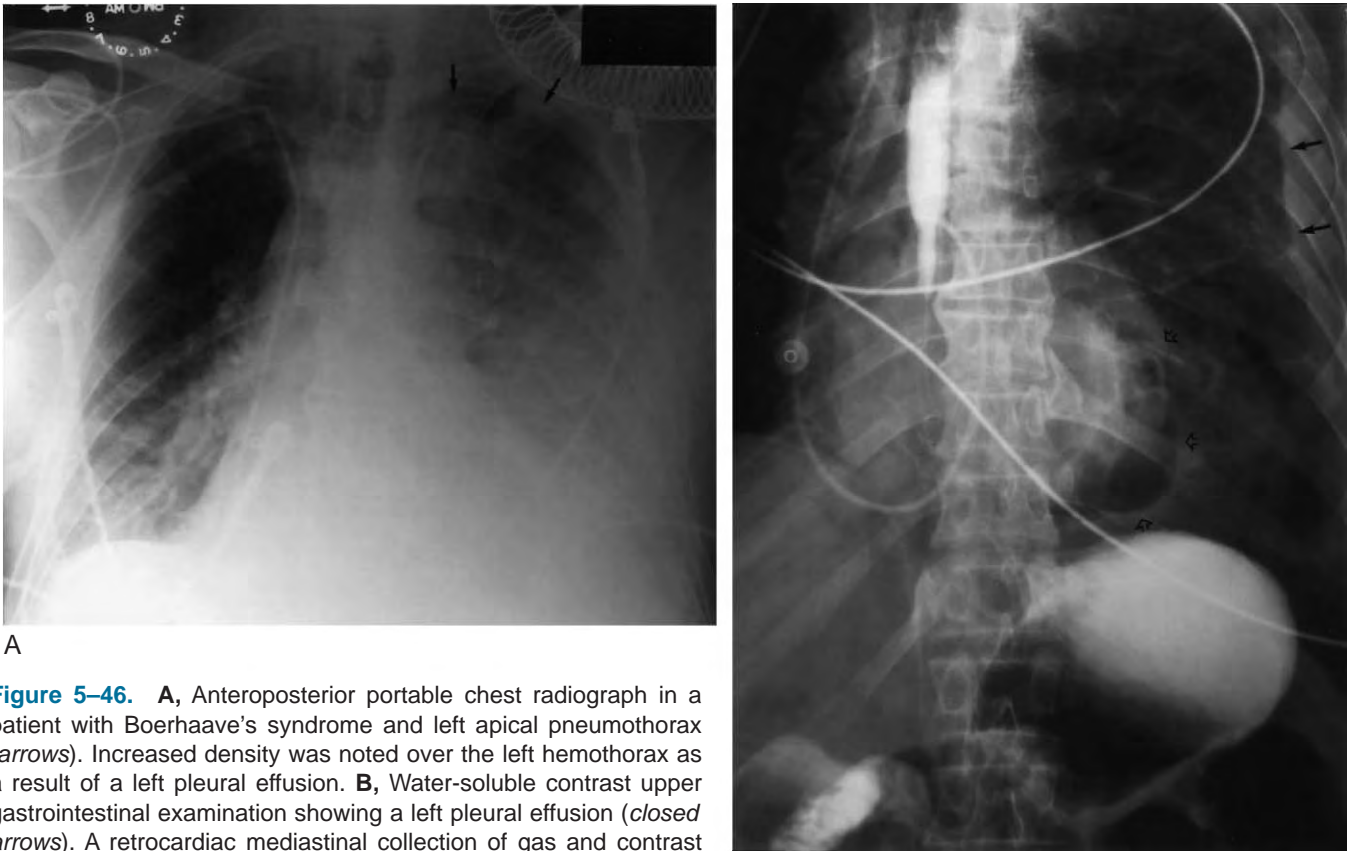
A, Anteroposterior portable chest radiograph in a patient with Boerhaave's syndrome and left apical pneumothorax (arrows). Increased density was noted over the left hemithorax as a result of a left pleural effusion. B, Water-soluble contrast upper gastrointestinal examination showing a left pleural effusion (closed arrows). A retrocardiac mediastinal collection of gas and contrast medium (open arrows) is indicative of esophageal rupture.
